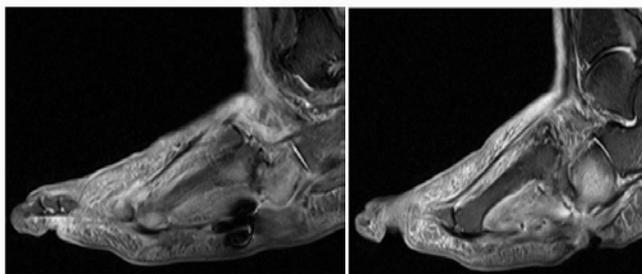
MRI revealing findings consistent with known neuropathic joint, surrounding cellulitis, and myositis with osteomyelitis of cuboid.
